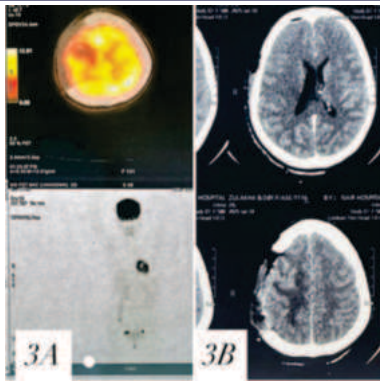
Postoperative imaging: (a) FDG-PET demonstrating uptake at the operative site and bilateral ovaries, (b) CT scan showing post-craniectomy status with gross total tumor excision.
